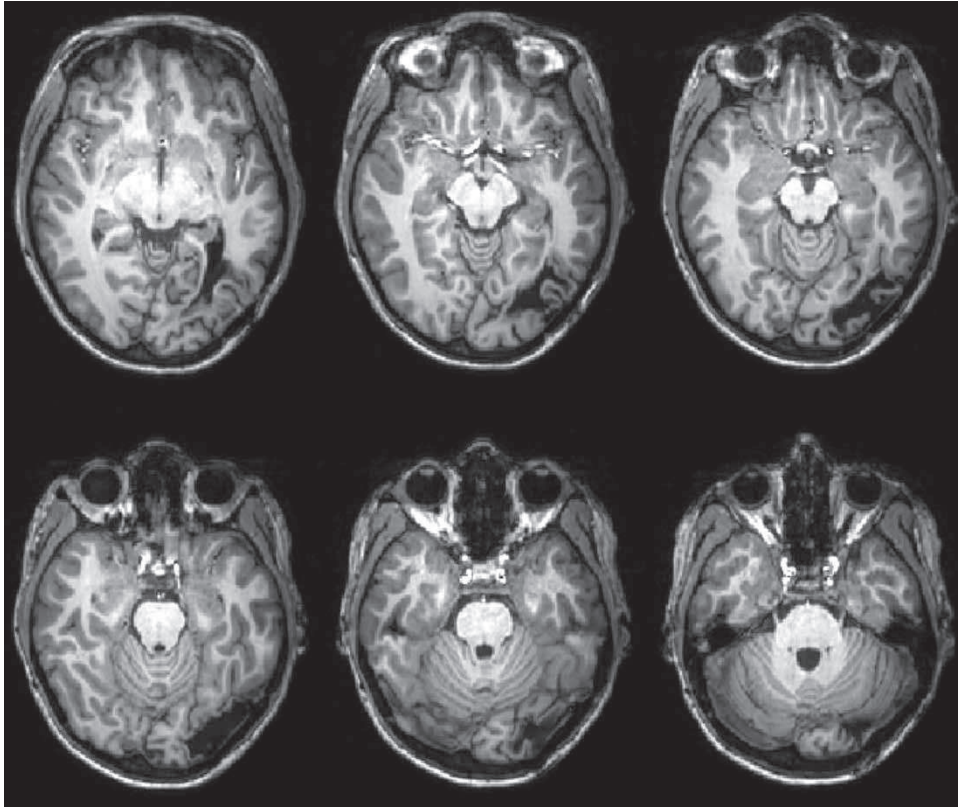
Magnetic resonance imaging (MRI) scan of patient L.K.'s lesion. Images are presented following radiological convention (left hemisphere depicted on the right).
